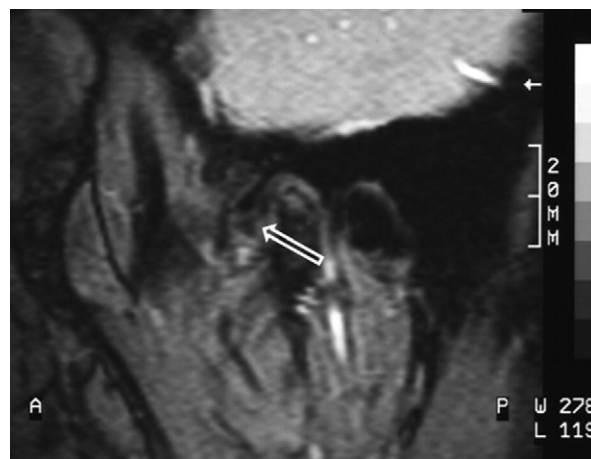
Magnetic resonance image of a temporomandibular joint disc displacement (arrow) in closed mouth of a patient with anterior disc displacement with reduction. The posterior band appears thinned.
